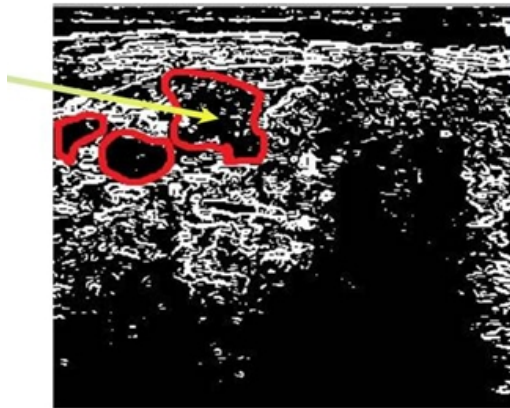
Contours of the patient ultrasound examinations results
